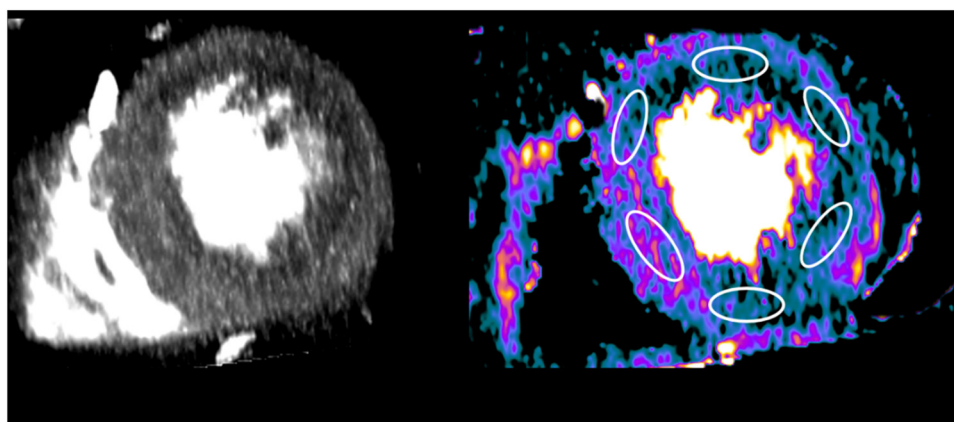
A representative example of myocardial blood flow (MBF) measurement on the dynamic myocardial computed tomography perfusion (CTP) images. Circular regions of interest (ROIs) measuring  $50 \text{ mm}^2$  were placed within the mid anterior, anterolateral, inferolateral, inferior, inferoseptal, and anterosseptal segments.
